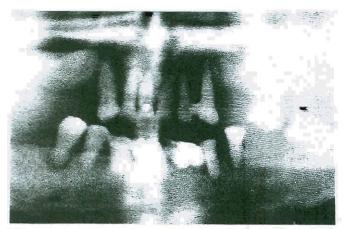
A pre-operative panoramic radiograph reveals an adequate quantity of mandibular alveolar bone of good density for immediate placement of blade implants after removal of the remaining periodontally compromised teeth.
